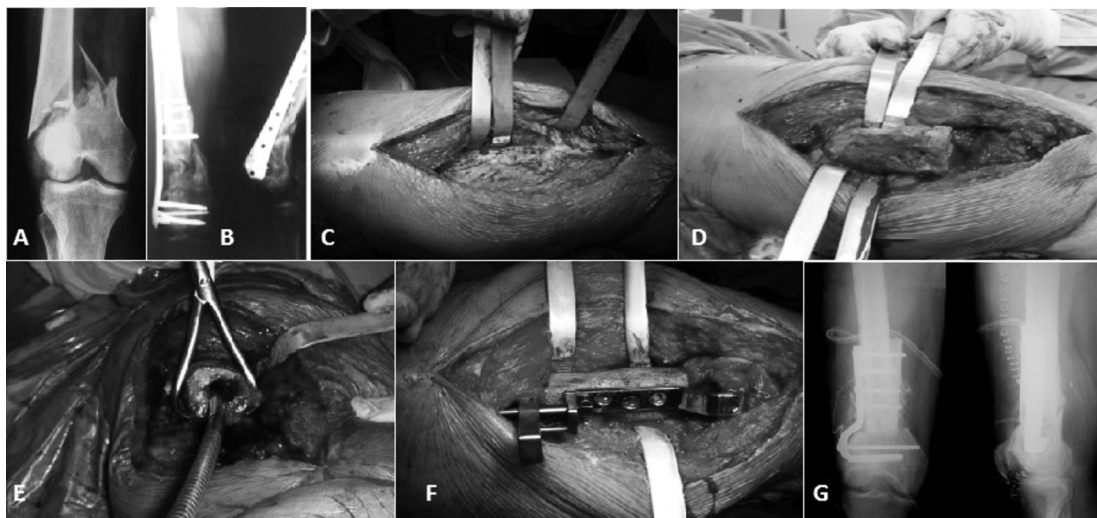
A) X-rays of distal femur's supra condylar fracture (33.A3 according AO/ OTA) in 62 years old male; B) fracture with a plate and screws (LISS) hesitated in non-union after 9 months after surgical treatment; C) exposure of plate and wires for removal per via modified para vastus lateralis approach; D) exposure of the proximal segment of the nonunion; E) reaming of the medullary canal; F) implant of plate blade system; G) X-rays of post-operative (Rollo G, 2014)
